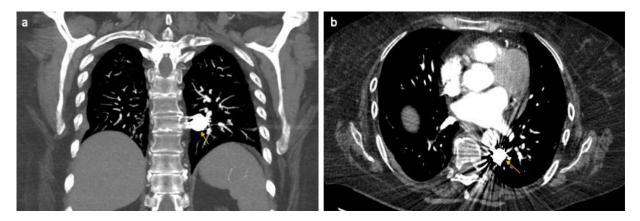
Contrast-enhanced CT images (A, B) show an embolization coil (yellow arrows) in the parenchyma of the medial left lower lobe 4 months after the procedure. No evidence of pulmonary embolism, acute consolidation, or abnormal lesion was found.
